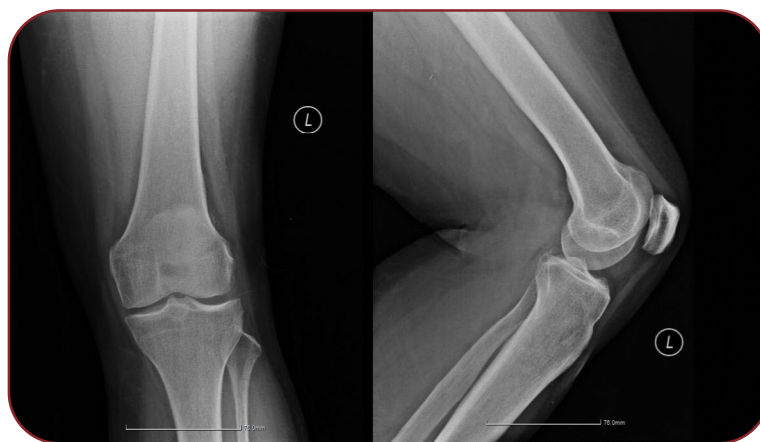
Preoperative anteroposterior and lateral radiographs of the left knee
